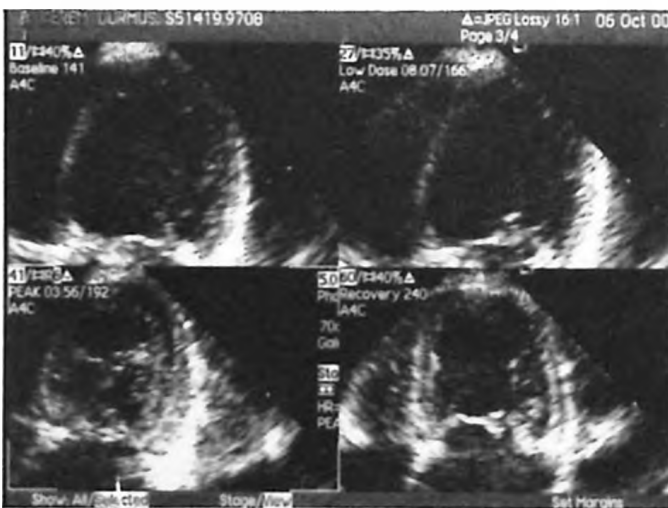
Dobutamine stress echocardiography apical four-chamber views at the beginning of study, at low dose ( $5 \mu\text{g}/\text{kg}/\text{min}$ ) dobutamine infusion, at maximum dose ( $40 \mu\text{g}/\text{kg}/\text{min}$ ) infusion and at the end of recovery period. No wall motion abnormality can be seen.
